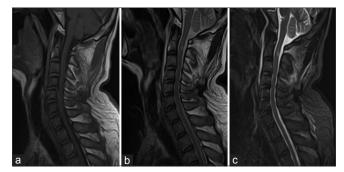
Sagittal magnetic resonance images of the cervical spine obtained 5 days after craniotomy. No abnormal findings were detected on (a) T1-weighted imaging or (b) T2-weighted imaging, (c) high-signal intensity was shown at the C3–C4 posterior structure on T2 fat-suppression sagittal magnetic resonance imaging, suggesting a posterior ligament complex injury
